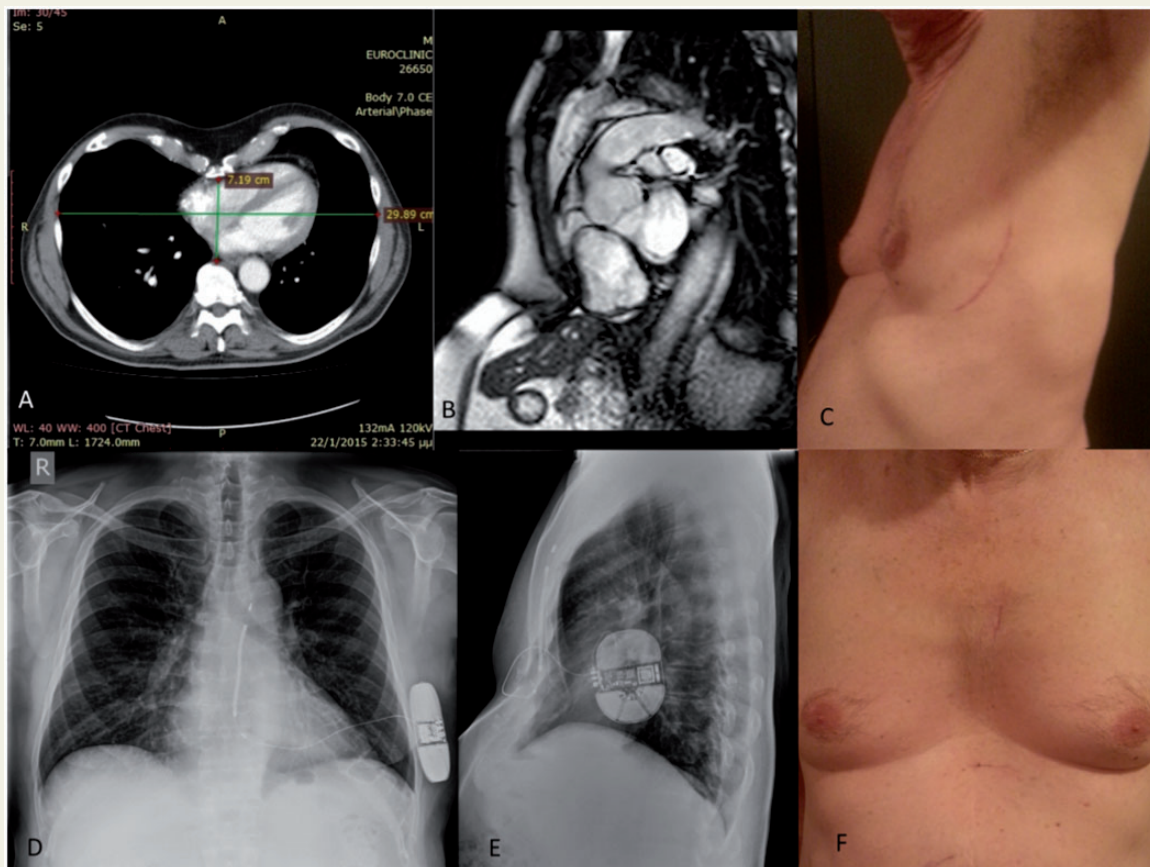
(A) Chest computed tomography was used to assess the severity of pectus excavatum (Haller index: 4.15). (B) Chest magnetic resonance imaging (lateral view). (C and F) Anterior and lateral view of patient's chest at 3 months follow-up. (D and E) Chest X-ray post implantation, anterior and lateral view, respectively. Note the close proximity of the lead to the sternum.
